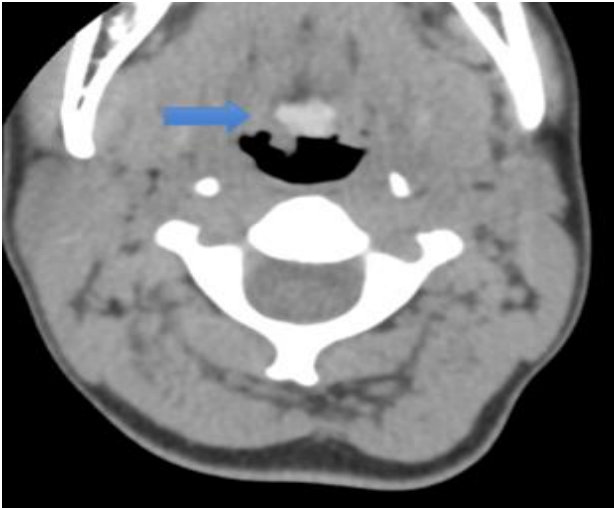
Axial CT neck of ectopic thyroid at the base of tongue region.
